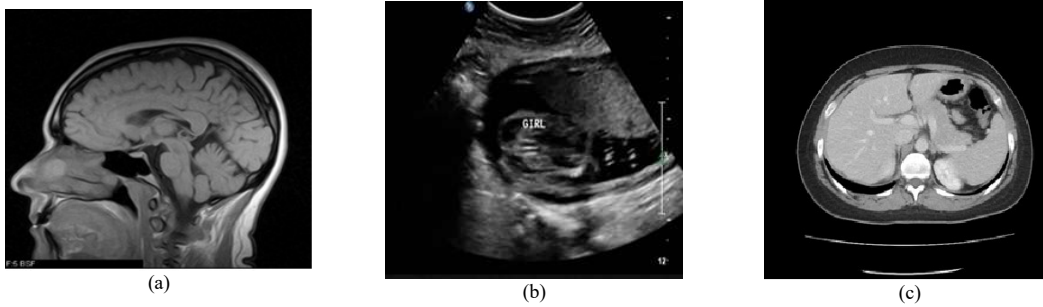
Watermarked images: (a) MRI of brain (b) Ultrasound of uterus (c) CT of liver
